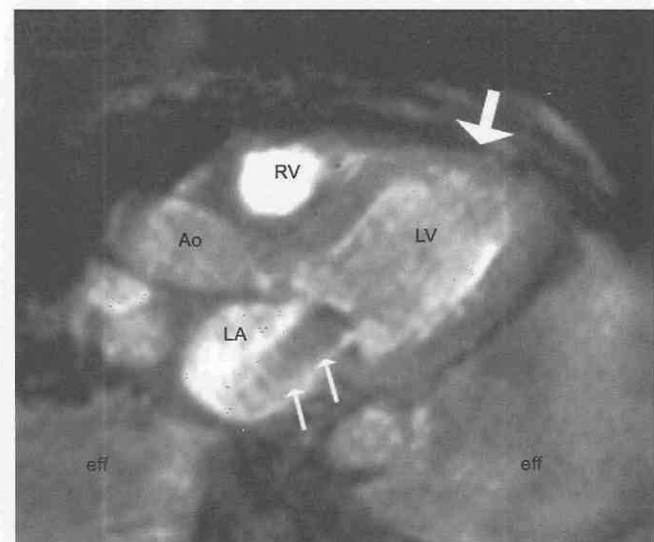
MR image demonstrating acute mitral regurgitation in a 52-year-old man suffering an acute myocardial infarction. Systolic oblique axial gradient-echo acquisition. A signal void jet (small arrows) extends from the mitral annulus into the normal-appearing left atrium (LA). Although left ventricular (LV) size is normal, the anteroseptal wall (large arrow) is aknetic. Ao, aorta; eff, pleural effusion; RV, right ventricle.
